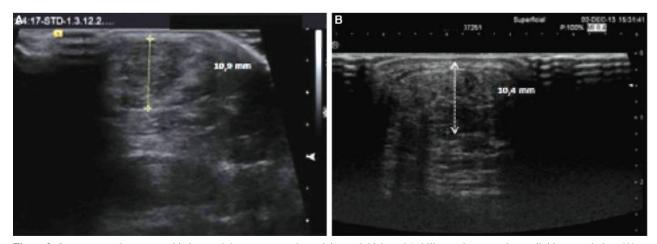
On tranverse ultrasonographic images inhomogenous echogenicity, and thickened Achilles tendon secondary to lipid accumulation. (A) Case 7: 10.9 mm-thick Achilles tendon, (B) Case 5: 10.4 mm-thick Achilles tendon
